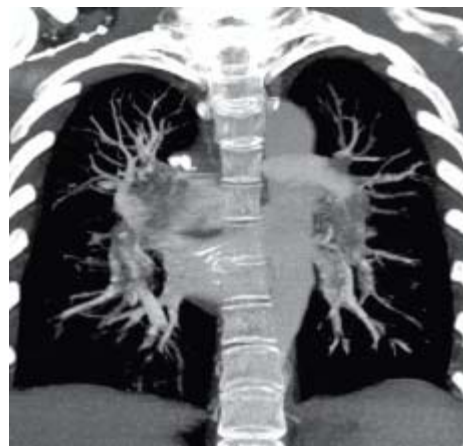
MIP-CT image accurately depicts multiple massive pulmonary emboli
